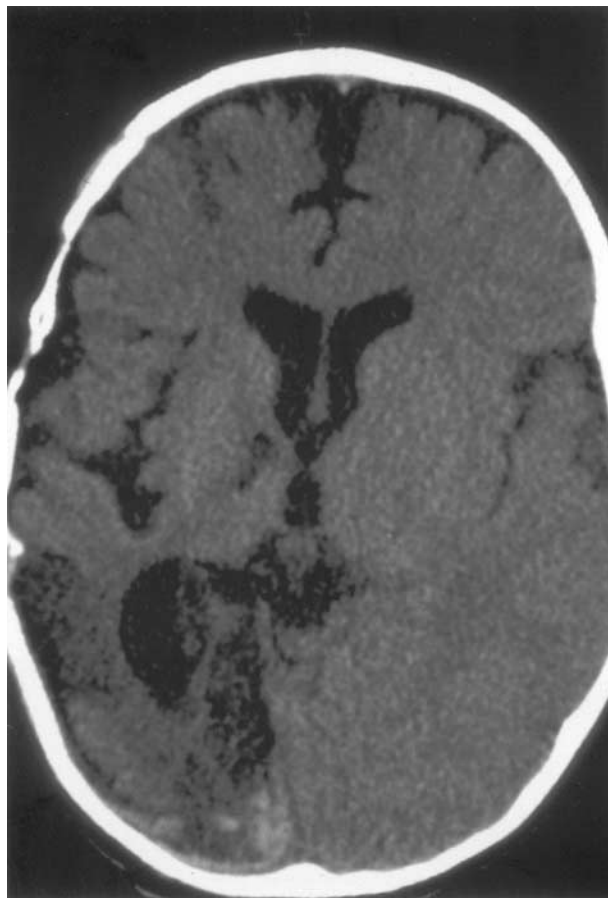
Three Months After His Initial Cranial Injury, This 20-Month-Old Male Struck His Forehead Against a Low Windowsill During Physical Therapy. He Cried Immediately and Was Not Easily Consoled. Over the Following Week, He Remained Persistently Irritable With Decreased Appetite. Cranial CT Imaging Several Days After This Witnessed, Minor Fall Revealed an Acute, Right Occipital, Subdural Hematoma in the Region of His Maximal Cerebral Atrophy.
